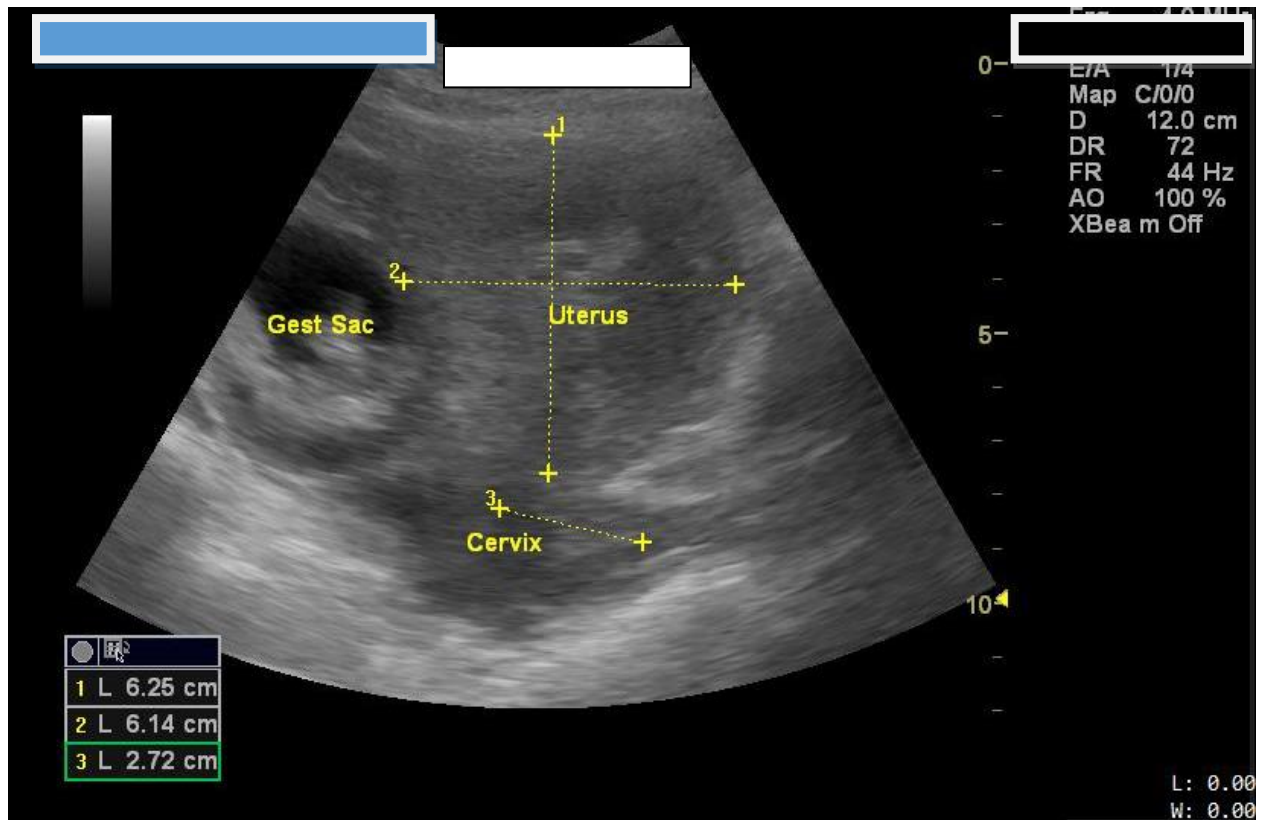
Pelvic ultrasound showing measurement of empty uterus and a right adnexial gestational sac with a live fetus with cardiac activity
